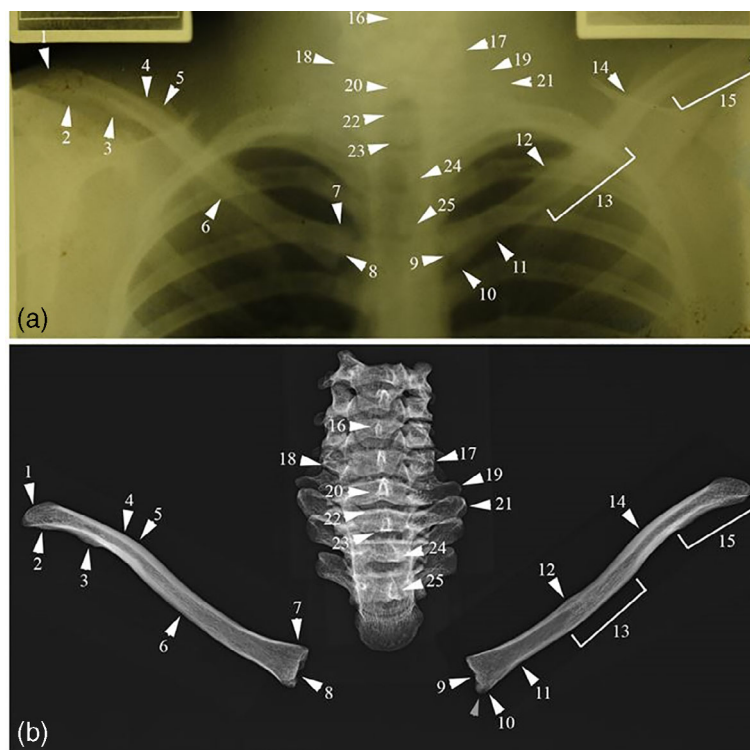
Example of a chest radiograph comparison. (a) Antemortem radiograph, (b) postmortem radiograph. The arrows and numbers correspond to points of concordance detailed in the chest radiograph report (CXR)
